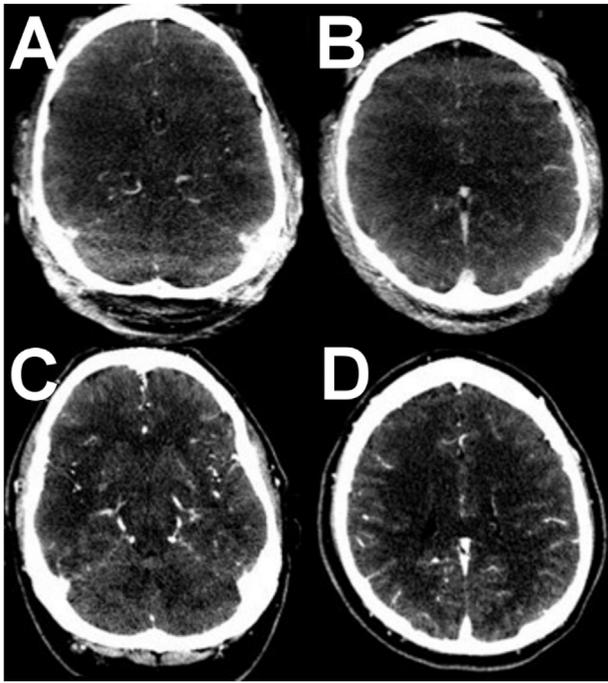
Discrepancy in Collateral Scores Between Dyna CTA and CTA. (A, B) Dyna CTA of patient with a right MCA M1 occlusion read as collateral score of 0, 1, and 1. (C, D) Corresponding matched CTA slices read as collateral scores of 4, 2, and 3.
